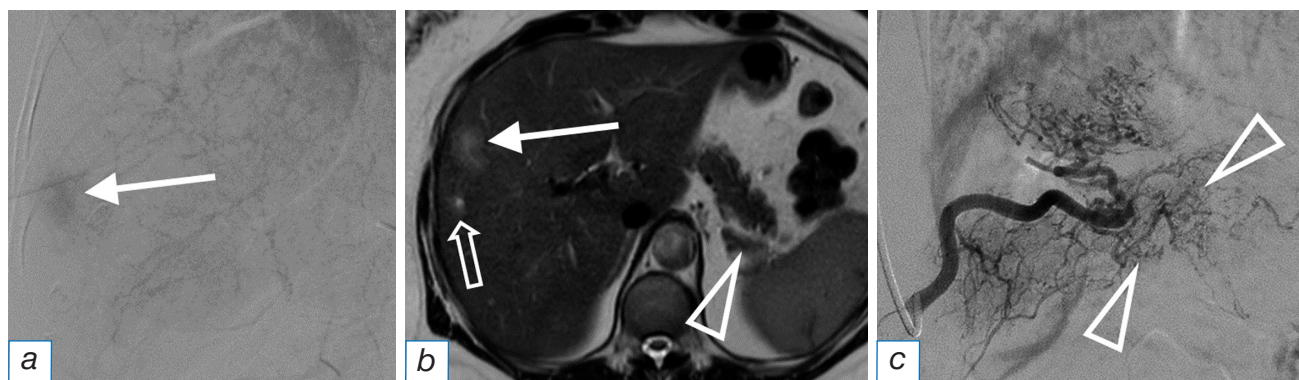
Angiography (a): intense contrast of a metastasis with a diameter of 3 cm (white arrow); magnetic resonance imaging (b): the same metastasis with a diameter of 3 cm with slit necrosis in the structure (long arrow), an infiltrative metastasis with a diameter of 0.5 cm with a locally expanded bile duct in the center (3D arrow), the pancreatic tail tumor (triangular arrow); angiography of the pancreatic tumor (c): branched network of afferents (triangular arrows).
